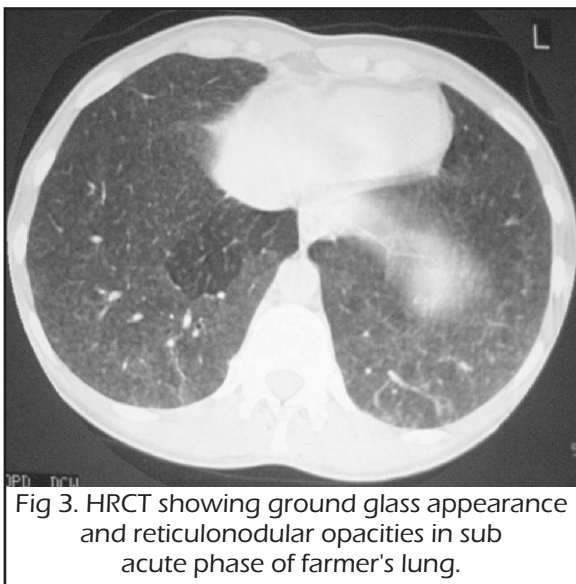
HRCT showing ground glass appearance and reticulonodular opacities in sub acute phase of farmer's lung.
